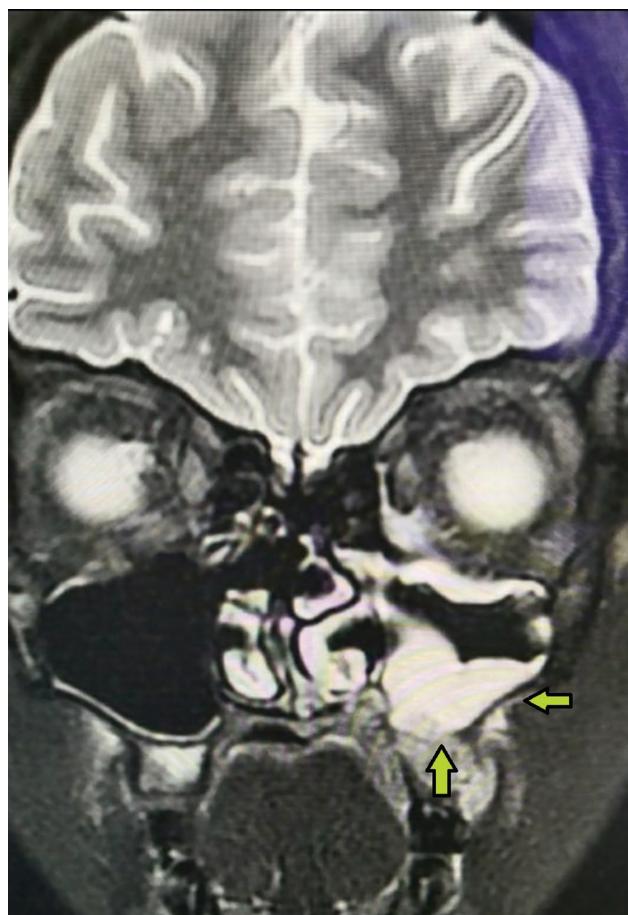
Markedly inflamed and hypertrophic mucosa of the left maxillary sinus cavity were noted on magnetic resonance imaging. The arrows point to the lateral and inferior sides of the left maxillary sinus.
